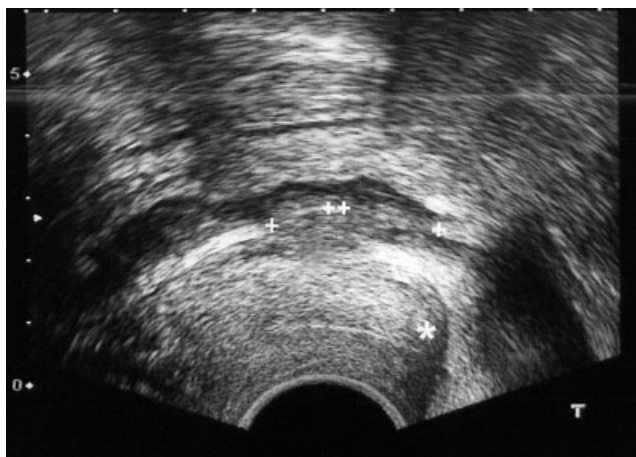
Transvaginal sonography showing a thickened, hypoechogenic irregular structure (++) disrupting the echo of the posterior vaginal wall (+) situated posterior to the cervix (*), corresponding to an endometriotic lesion involving the upper part of the posterior vaginal fornix also infiltrating the adjacent rectosigmoid.
